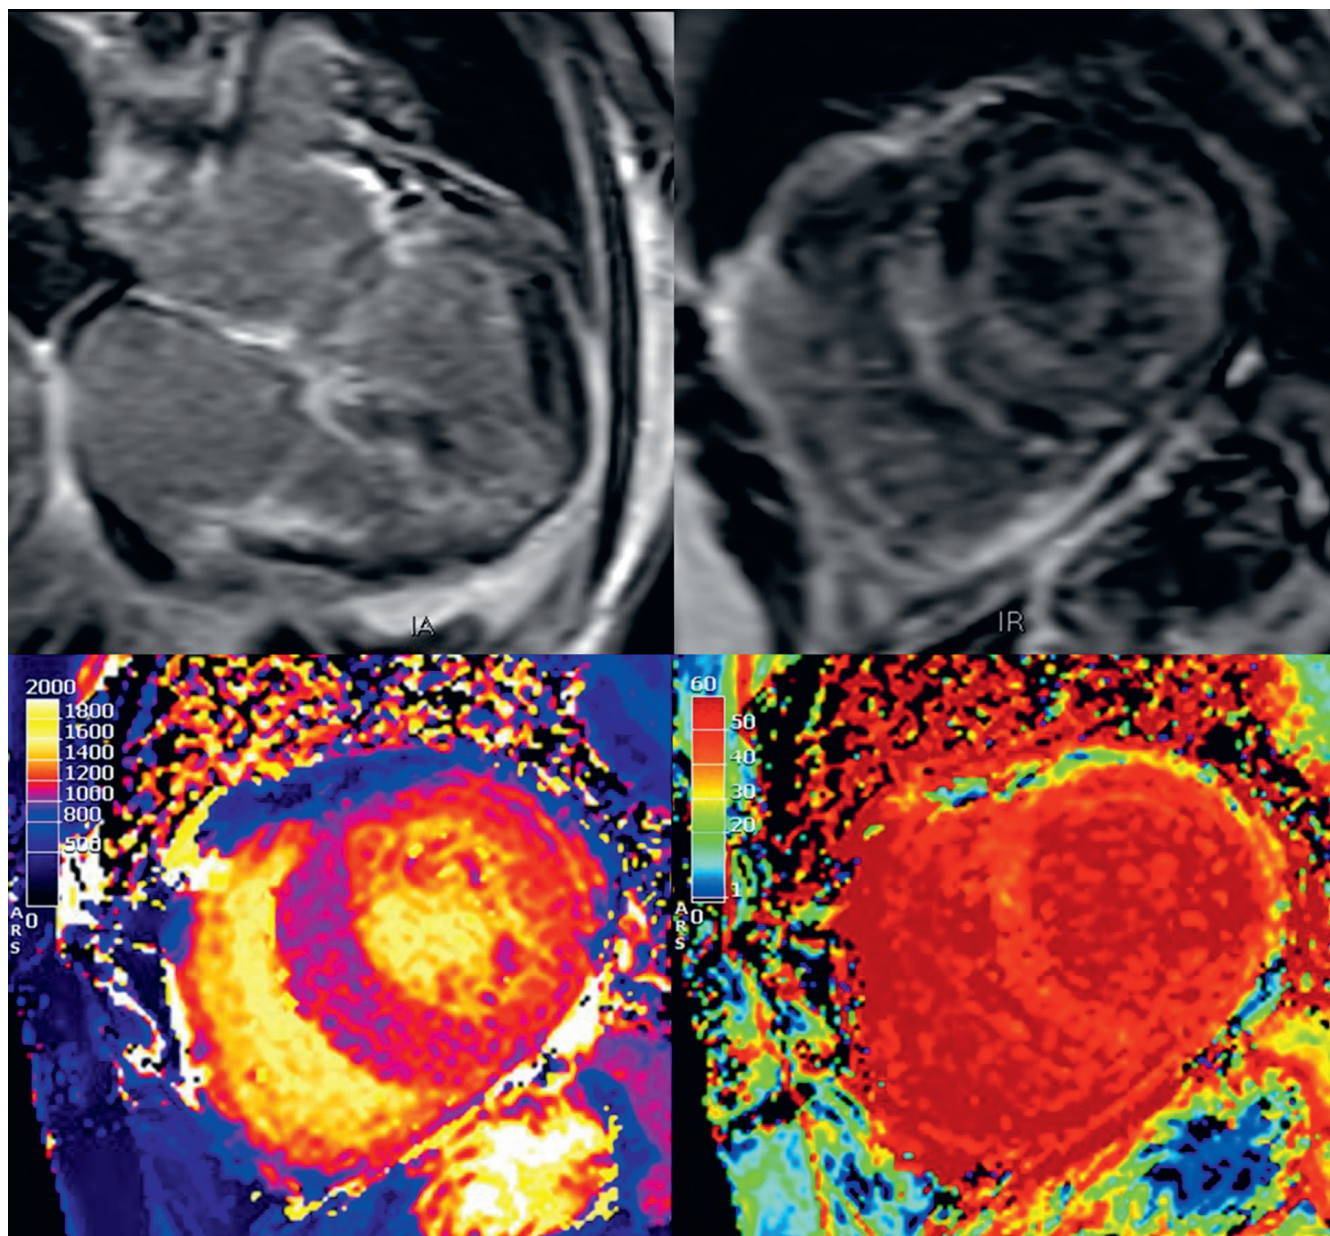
Magnetic resonance imaging (MRI) of the heart of a 73-year-old patient with cardiac amyloidosis (CA): concentric left ventricular (LV) hypertrophy with generalized diffuse and confluent foci of late post-contrast enhancement; late post-contrast enhancement visible also in the walls of the enlarged atria and the free wall of the right ventricle; thickened atrial septum; trace of fluid in the pericardial sac; native longitudinal relaxation time (T1) of 1110 ms (norm: 950–1040 ms); extracellular volume (ECV) of 45% (norm: 20–30%)
